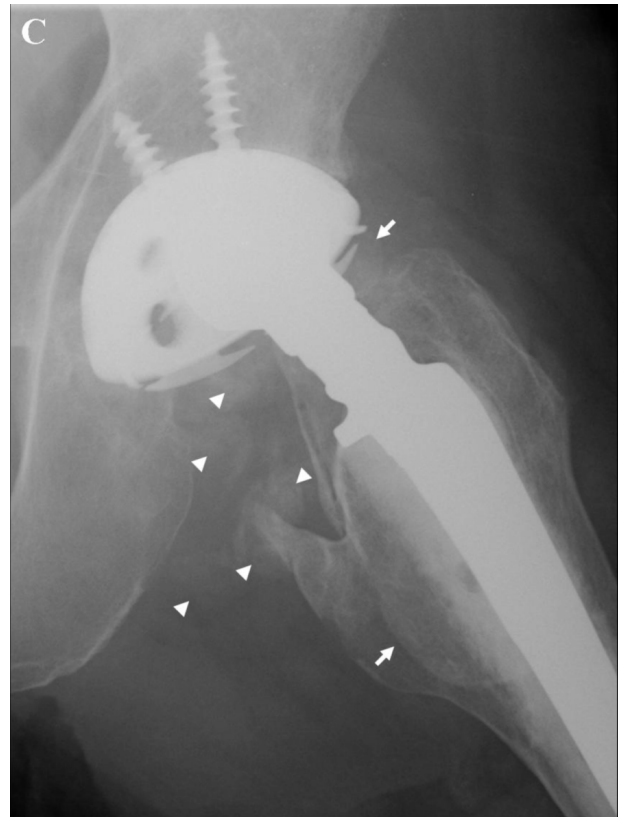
Frog-lateral radiograph of the right hip shows eccentric position of the femoral head within the acetabular cup. The bubble sign (arrows) and cloud sign (arrowheads) are present in the periprosthetic region of the left hip joint.
